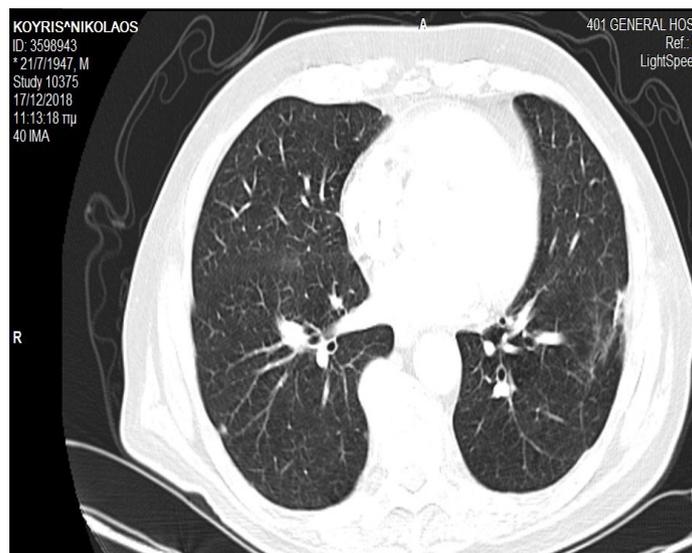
A chest CT scan after 10 months of treatment with TKIs showing partial remission of lung metastatic disease.
